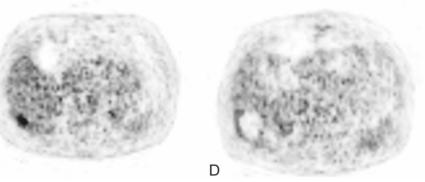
Evaluation after liver metastasectomy. PET/CT (A, C) and PET (B, D) images before (A-B) and 4 days after metastasectomy (C-D).
